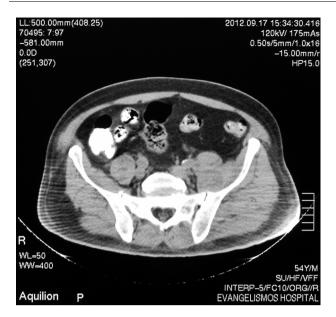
The abdominal CT scan depicting an abscess of the left iliopsoas muscle.
